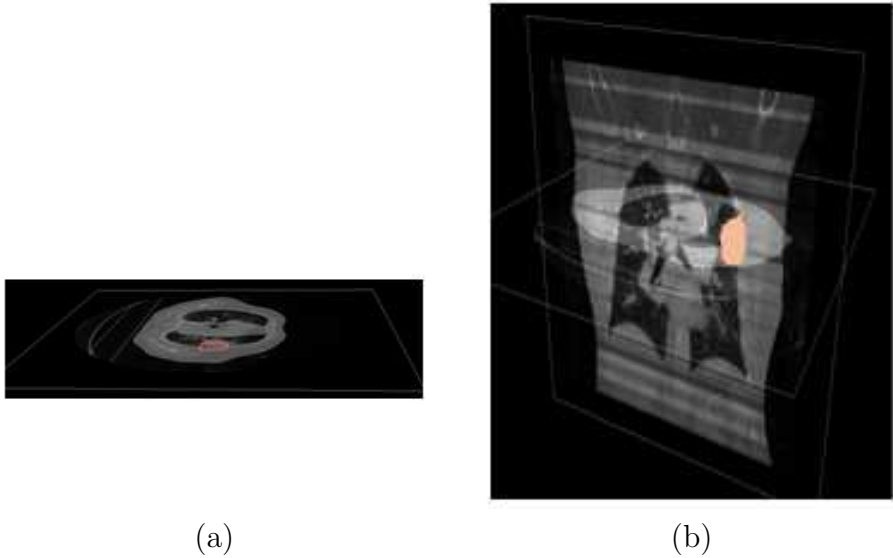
Tumor segmentation from CT images. (a) Segmentation performed in 3D; the red solid is the tumor; (b) segmentation visualized in a cross-section.
